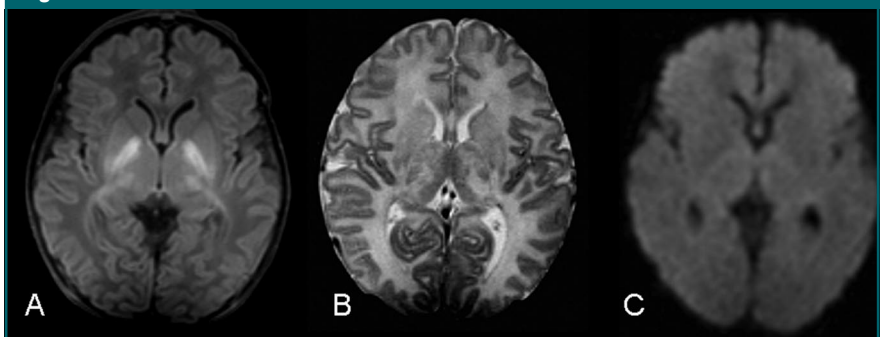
MR images at day 9 in an infant with basal ganglia and central cortex pattern of cerebral damage and a good motor outcome at the age of 2 years. *A*, T1-weighted image with an abnormal high signal intensity in the globus pallidus and, to a lesser extent, in the thalamus. *B*, T2-weighted image with an irregular, abnormal high signal intensity in the thalamus and, to a lesser extent, in the globus pallidus. *C*, DW image ($b = 1000 \text{ sec}/\text{mm}^2$) without abnormalities.
